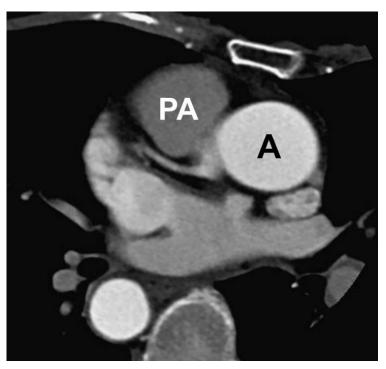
CT axial image shows Inversion of the great vessels: the aortic root(A) is located posterior and rightward to the main pulmonary trunk(PA), at the level of the valves, which is designated as situs inversus of great vessels "{__,_,I}".
